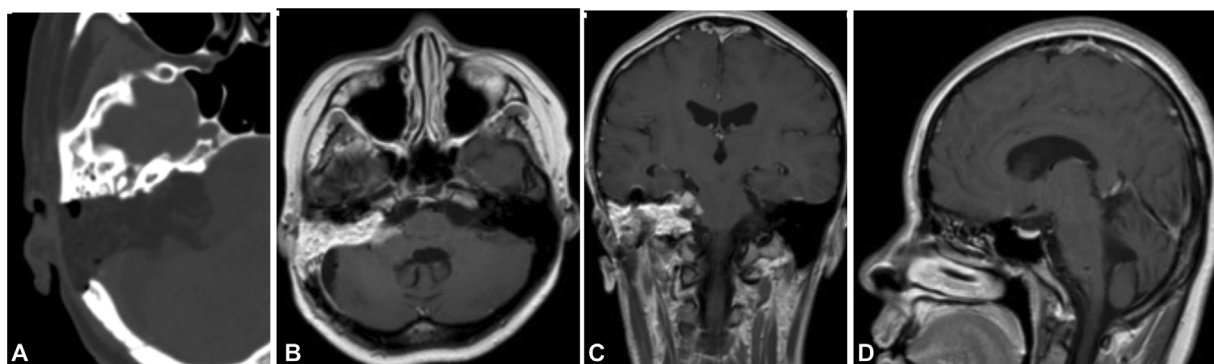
Postoperative imaging after TL-RS resection of patient 21. (A) Postoperative CT scan of the right mastoid. (B) Axial T1-weighted gadolinium-enhanced MRI. (C) Coronal T1-weighted gadolinium-enhanced MRI. (D) Sagittal T1-weighted gadolinium-enhanced MRI. CT, computed tomography; MRI, magnetic resonance imaging; RS, retrosigmoid; TL, translabyrinthine.
